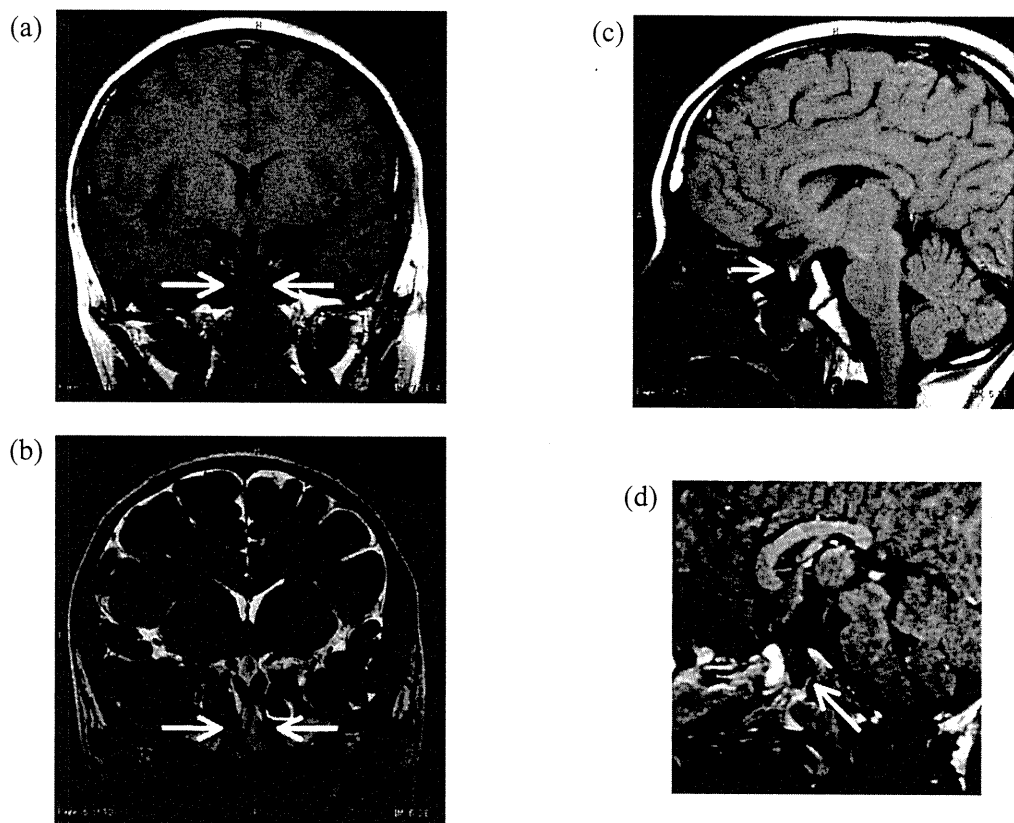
T1-weighted (a) and T2-weighted (b) coronal and T1-weighted sagittal (c) MRI revealed a cystic mass with a surrounding structure extending through the bone defect into the epipharynx. The longitudinal diameter of the cystic mass was 3.5 centimeters. T1-weighted sagittal MRI at the age of 6 years (d) demonstrated a sphenoid cystic lesion 1.5 centimeters in diameter.
